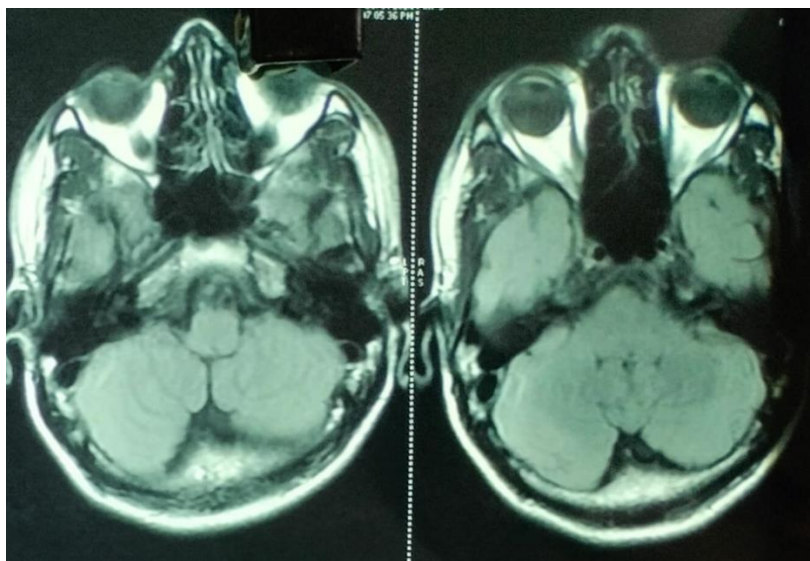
T2 FLAIR image showing normal scan of bilateral cerebellar hemispheres during follow-up study
